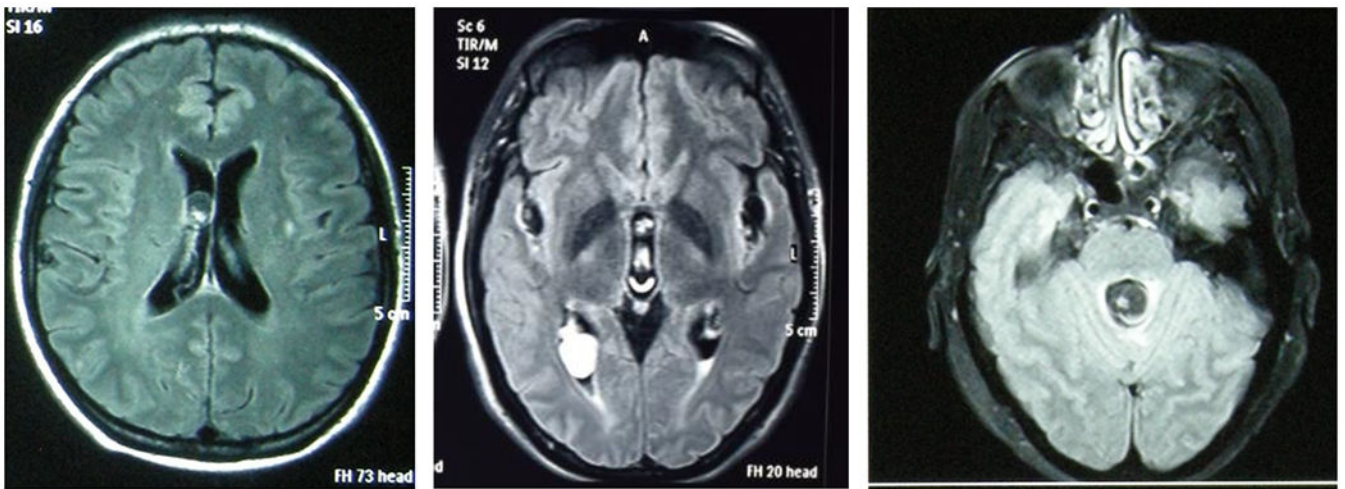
Ventricular NCC. Left-viable cyst in a lateral ventricle; Center - degenerating cyst in the occipital horn of the right lateral ventricle – note the change in the intensity of signal of the cyst contents; Right - IV ventricle cyst growing towards the aqueduct. All images are non-contrast MRI, FLAIR protocol.
